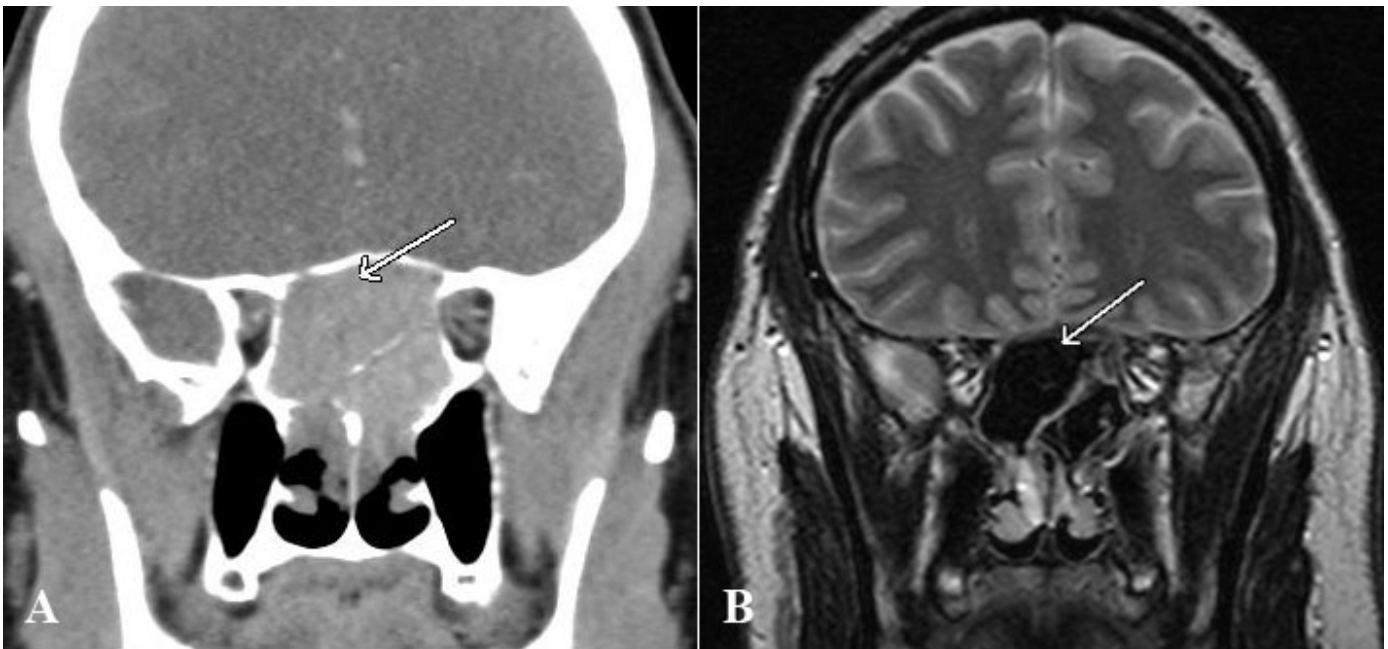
(A) CT in a patient with allergic fungal sinusitis leading to a sphenoid mucocoele. Note the markedly hyperdense secretions and the expanded bony margin (arrow). (B) T2 weighted MRI in the same patient demonstrates the limitations of MRI in the evaluation of benign sinus disease: the inspissated secretions filling the sphenoid sinus are so proteinaceous that they are very hypointense on T2 weighted imaging (arrow) and give the false impression that the sinus is aerated.
